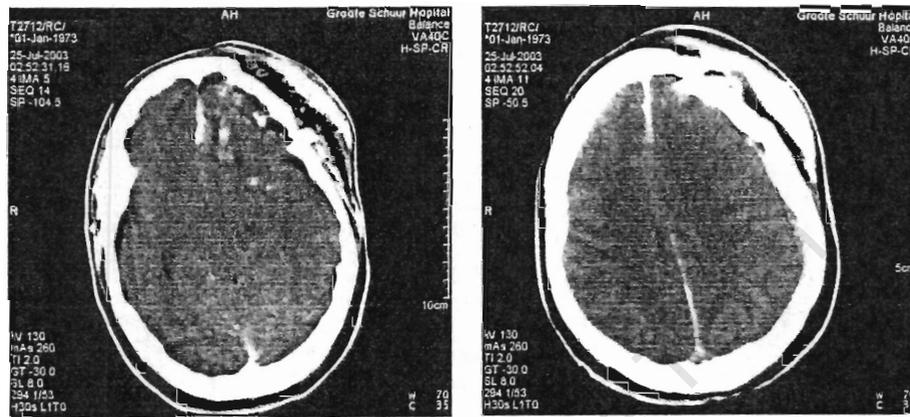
Pre-operative CT head scans of patient JZ
